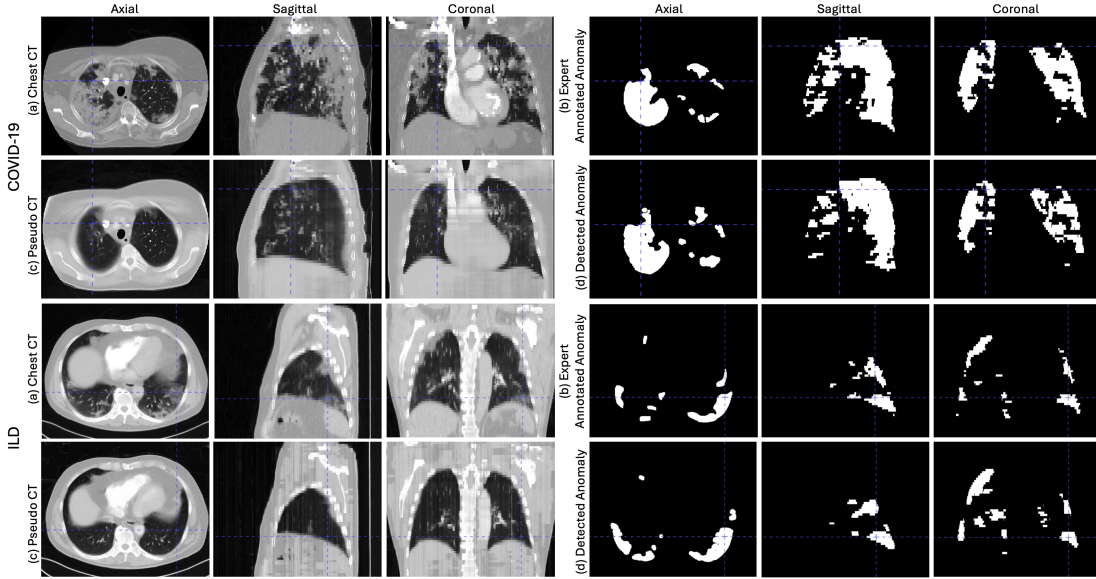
Examples of automatic anomaly detection using the proposed method. (a) 3D chest CT scan from a COVID-19 patient and an ILD patient; (b) Manually annotated anomaly map by radiologist; (c) Synthetic CT scan generated by the model, with anomalies suppressed; (d) Anomaly detected by our model.
